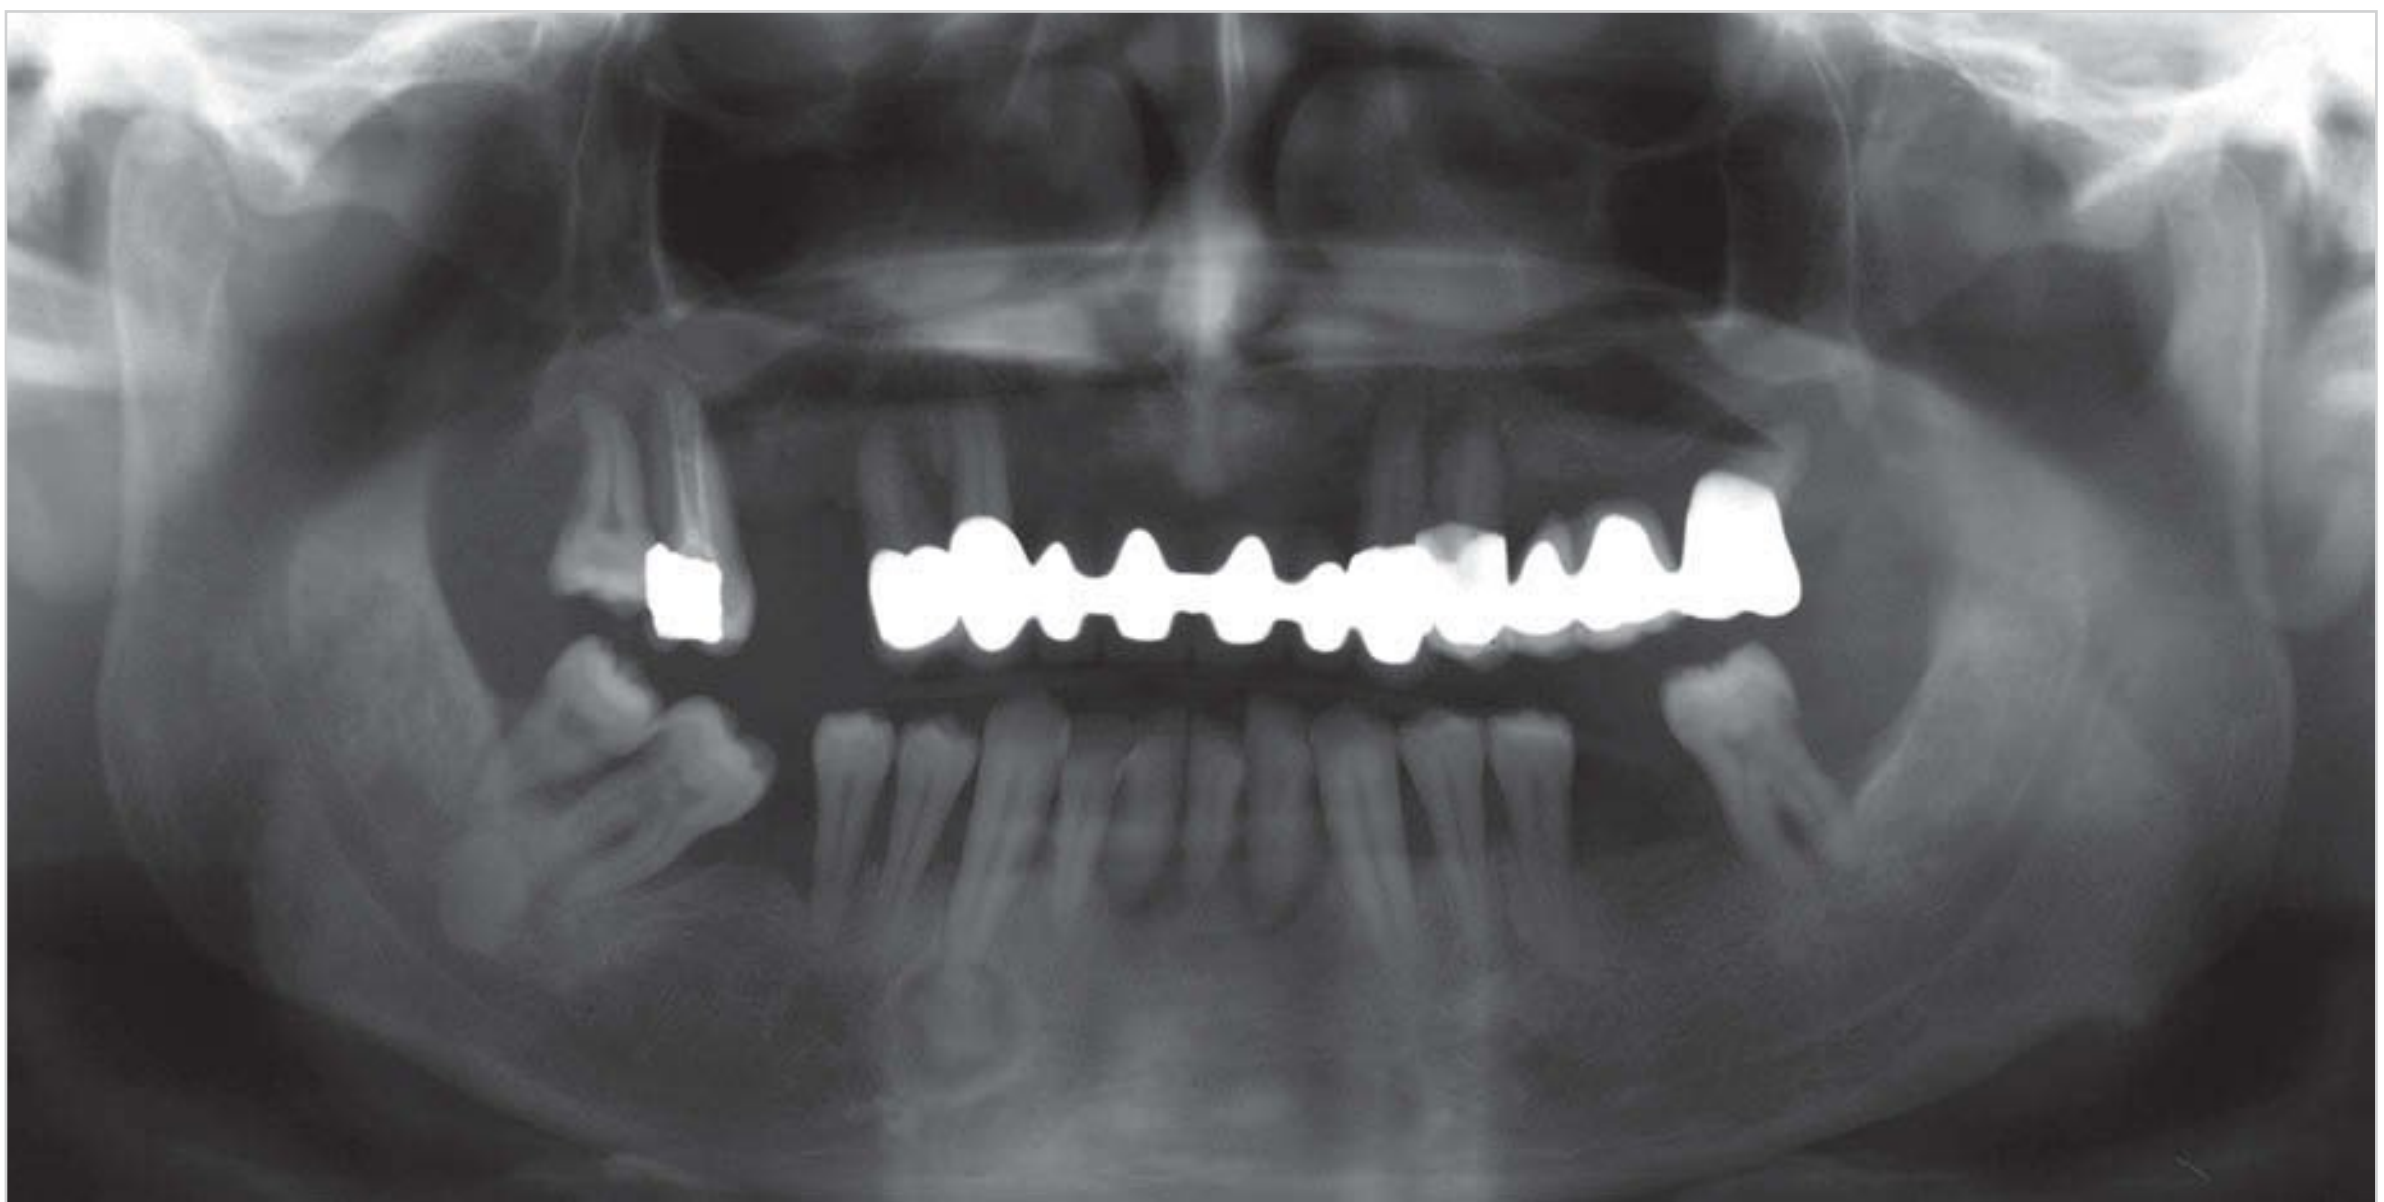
Cementoma (cementoblastoma): The radiograph reveals a radiopaque mass that is closely connected to the apex of tooth 43 and surrounded by a radiolucent margin.
